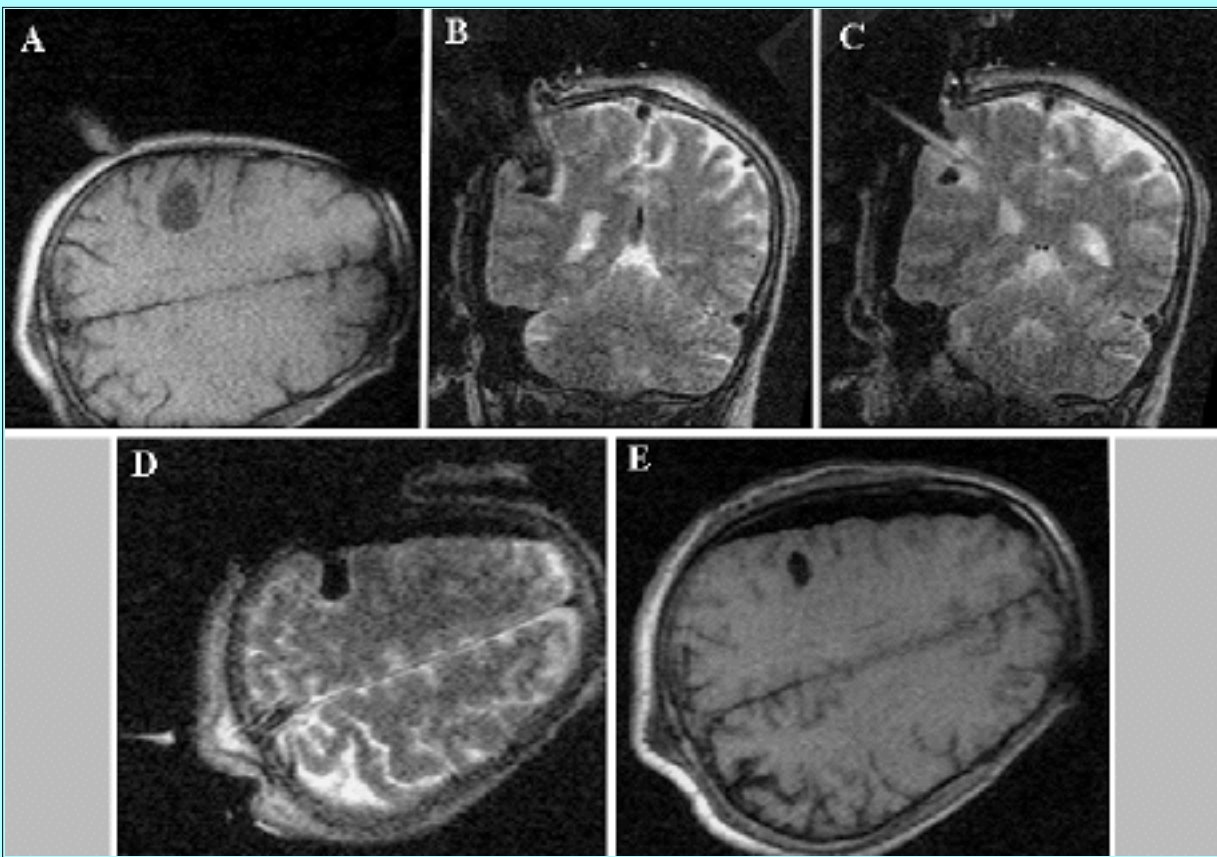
Magnetic resonance images showing the resection of an astrocytoma directly posterior to motor strip. A: Initial axial T_1 -weighted intraoperative image demonstrating a hypodense mass and finger for localization on the skin. B: A T_2 -weighted coronal image revealing a finger placed in the resection bed to localize remaining radiographically abnormal tissue. C: A T_2 -weighted image obtained to localize tissue still requiring resection with a syringe pointer. D: Axial T_2 -weighted image obtained to evaluate the completeness of resection prior to closing the dura. E: Final axial T_1 -weighted image postclosure showing a fluid-filled resection cavity. Note the degree of sag of the brain tissue.
